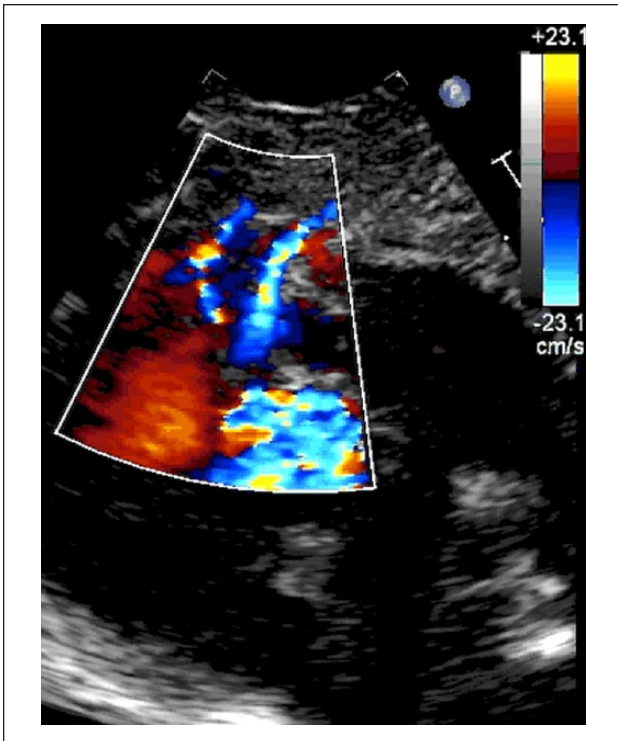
Parasternal short-axis color Doppler echocardiographic view in an infant with pulmonary atresia and intact ventricular septum at the level of the aortic root demonstrates reversal of flow in the right coronary artery and infundibular branch suggesting significant ventriculocoronary connections.
